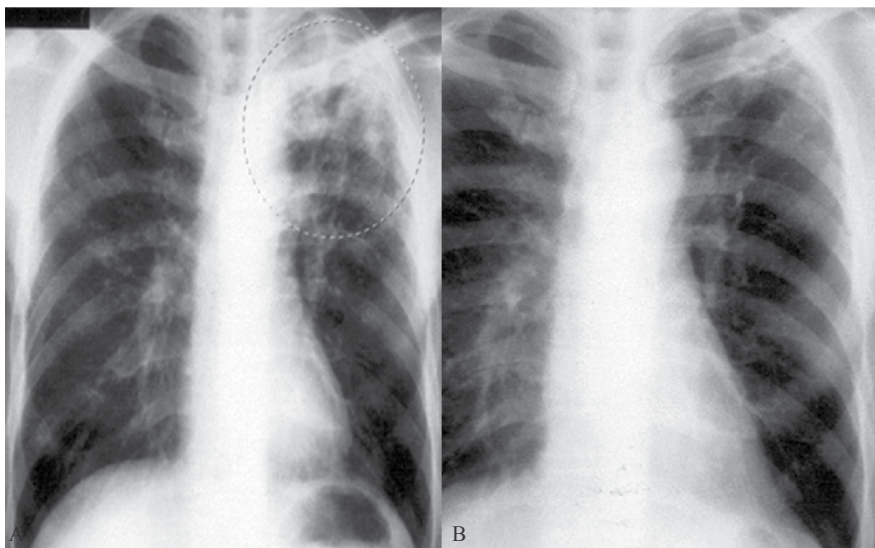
Chest X-ray of pulmonary tuberculosis and cured Tuberculosis A. before chemotherapy with rifampicin, isoniazide, ethambutol and pyrazinamide, B. after chemotherapy. Apical shadow (dotted circle) disappears.
